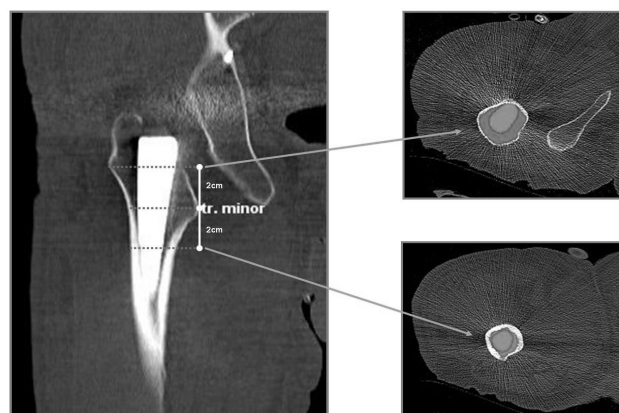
Calculation of stem area/ endosteal area in CT images.
